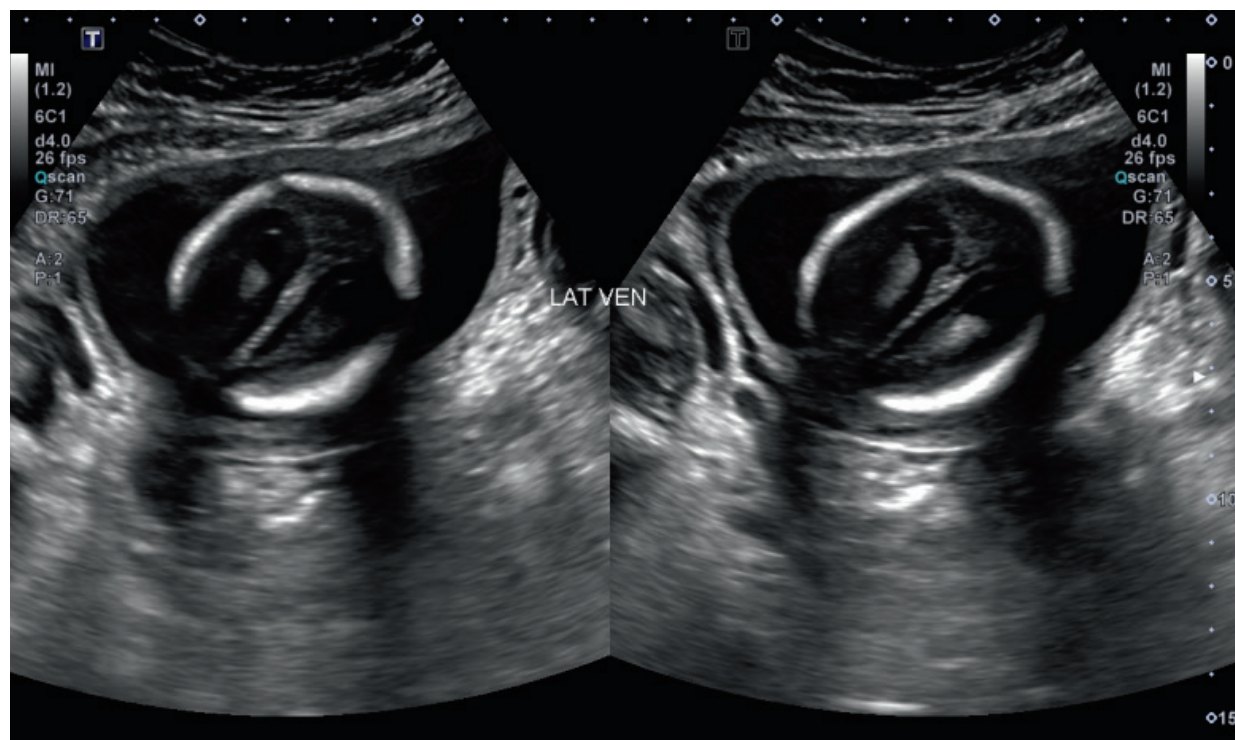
Axial ultrasound image of the fetal brain presenting mild ventriculomegaly in the lateral ventricles.
